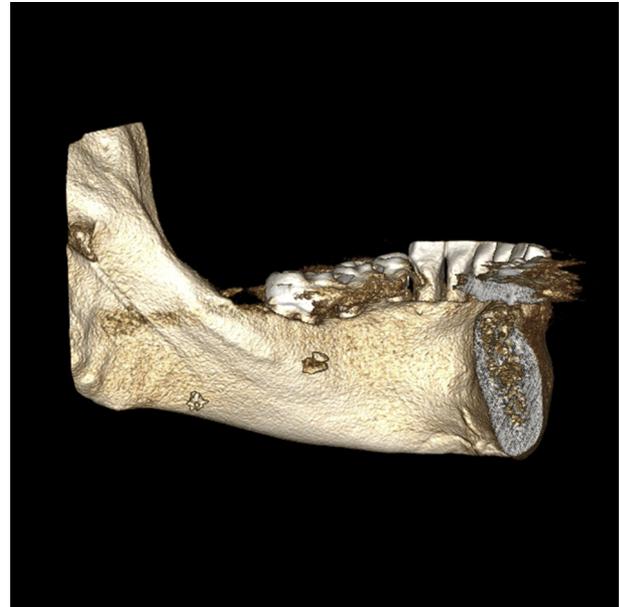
Patient 3. Cone-beam computed tomography image, 3-dimensional view of the medial aspect of the left mandible.
